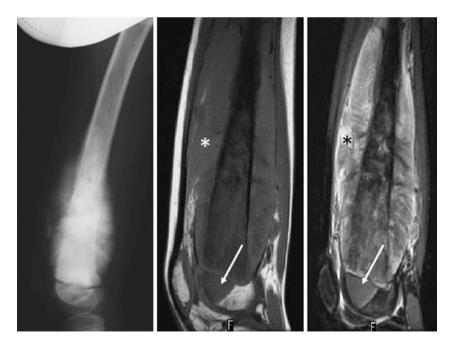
MRI: Sarcoma's spread
